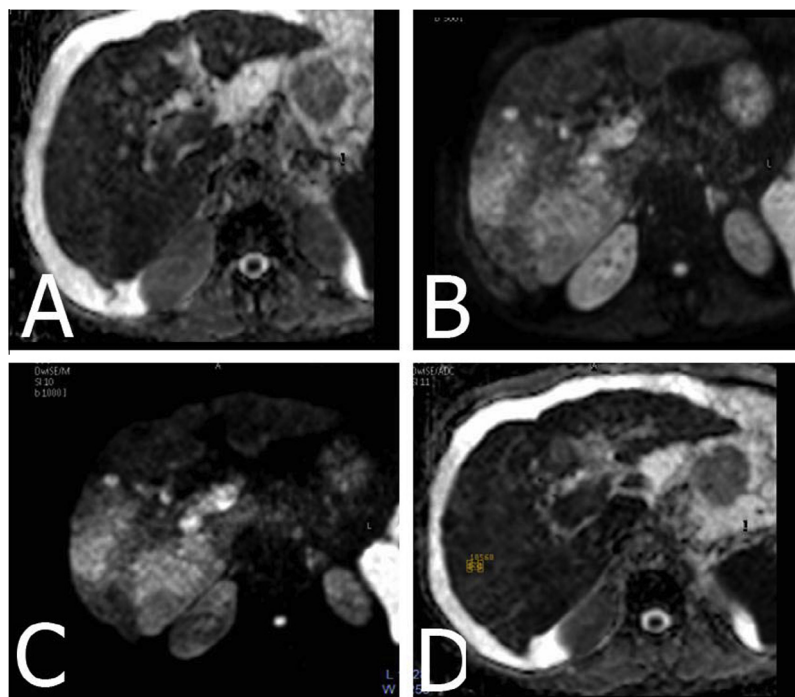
Diffusion weighted MR images of 60 year old male patient with HCC, DWI at b_0 (A), DWI at b_500 (B), DWI at b_{1000} (C) and ADC map (D) shows restricted diffusion with mean ADC value at $b_{1000} = 0.85 \times 10^{-3} \text{ mm}^2/\text{s}$.
